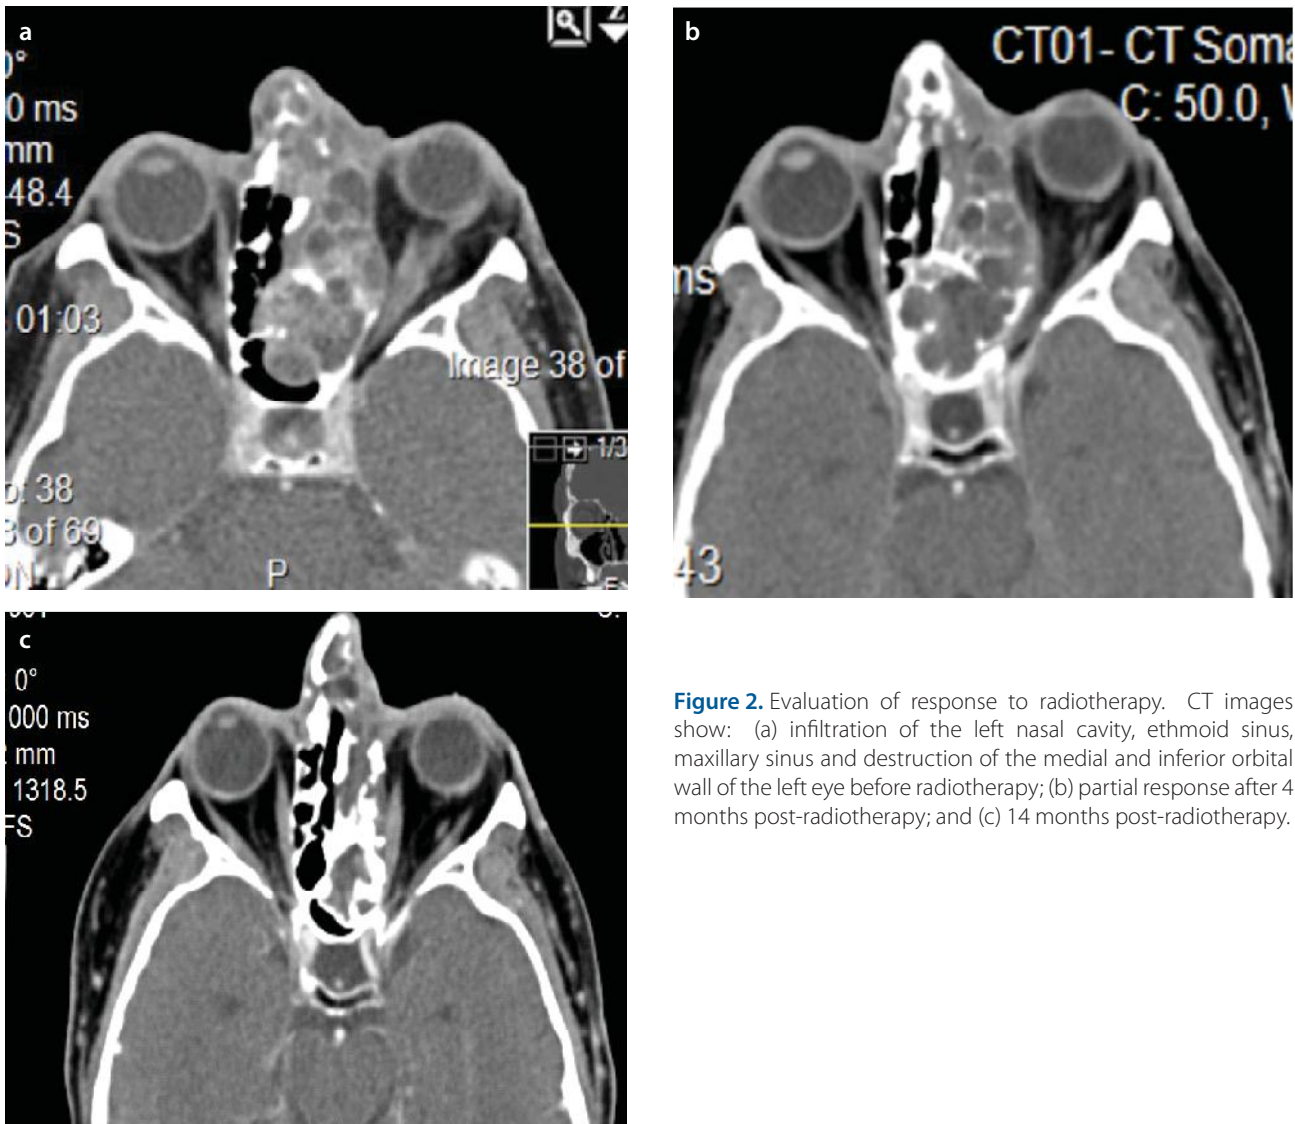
Evaluation of response to radiotherapy. CT images show: (a) infiltration of the left nasal cavity, ethmoid sinus, maxillary sinus and destruction of the medial and inferior orbital wall of the left eye before radiotherapy; (b) partial response after 4 months post-radiotherapy; and (c) 14 months post-radiotherapy.
